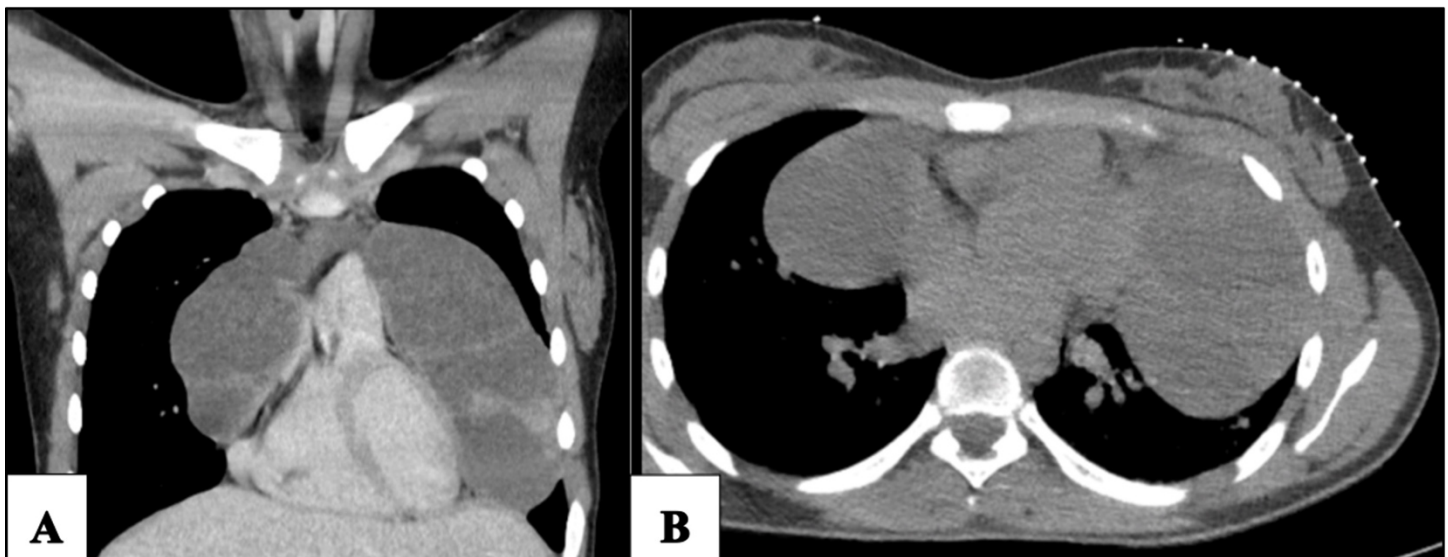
Computed Tomography (CT) of the chest. Axial view (A), and coronal view (B). Both views show a large anterior mediastinal mass crossing midline at the pulmonary trunk.
